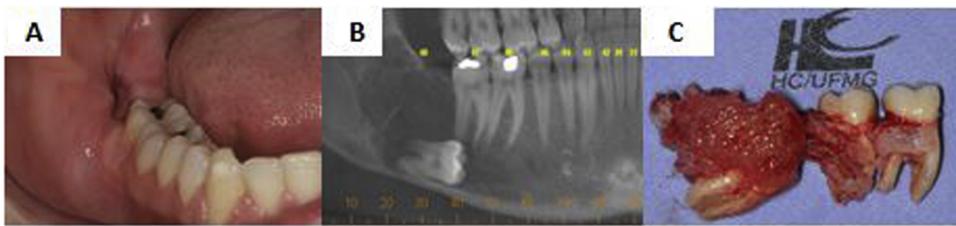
Case 2 general features. A: The patient did not present any clinical alterations. The element 48 was absent. B: Cone Beam computed tomography revealed a hypodense unilocular lesion causing the displacement of the right inferior third molar. C: Marginal resection after OM recurrence.
